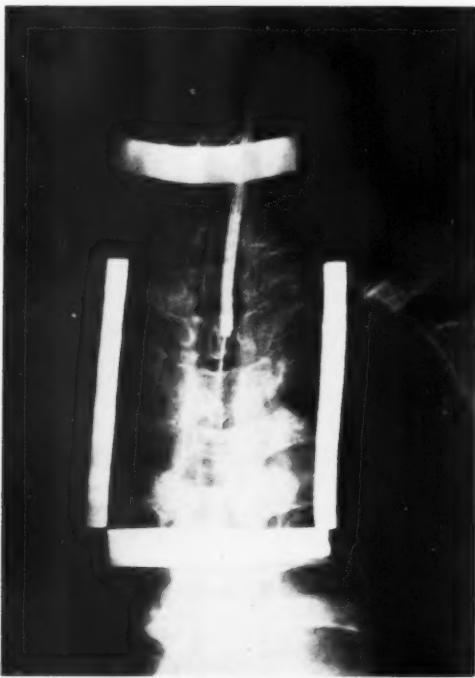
Radiograph obtained with a diagnostic unit, showing the position of the ionization chamber relative to the treatment field in an esophagus.
